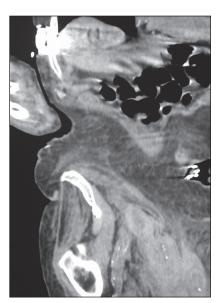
A coronal-view computed tomography scan of the abdomen and pelvis showing soft tissue extending from the pelvis into the scrotum via the inquinal canal.
